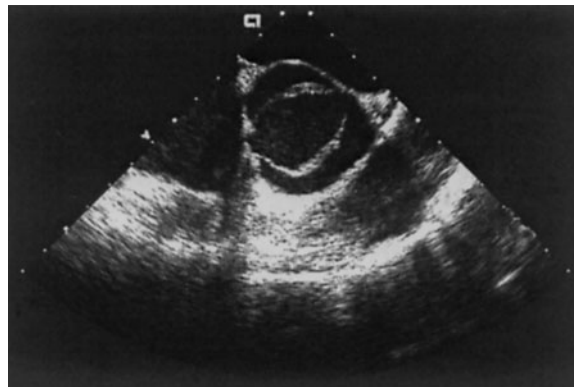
Transesophageal echocardiographic image of bicuspid aortic valve. Noncoronary cusp (at the tip of the viewing triangle) is freestanding, Left and right coronary cusps are fused.
